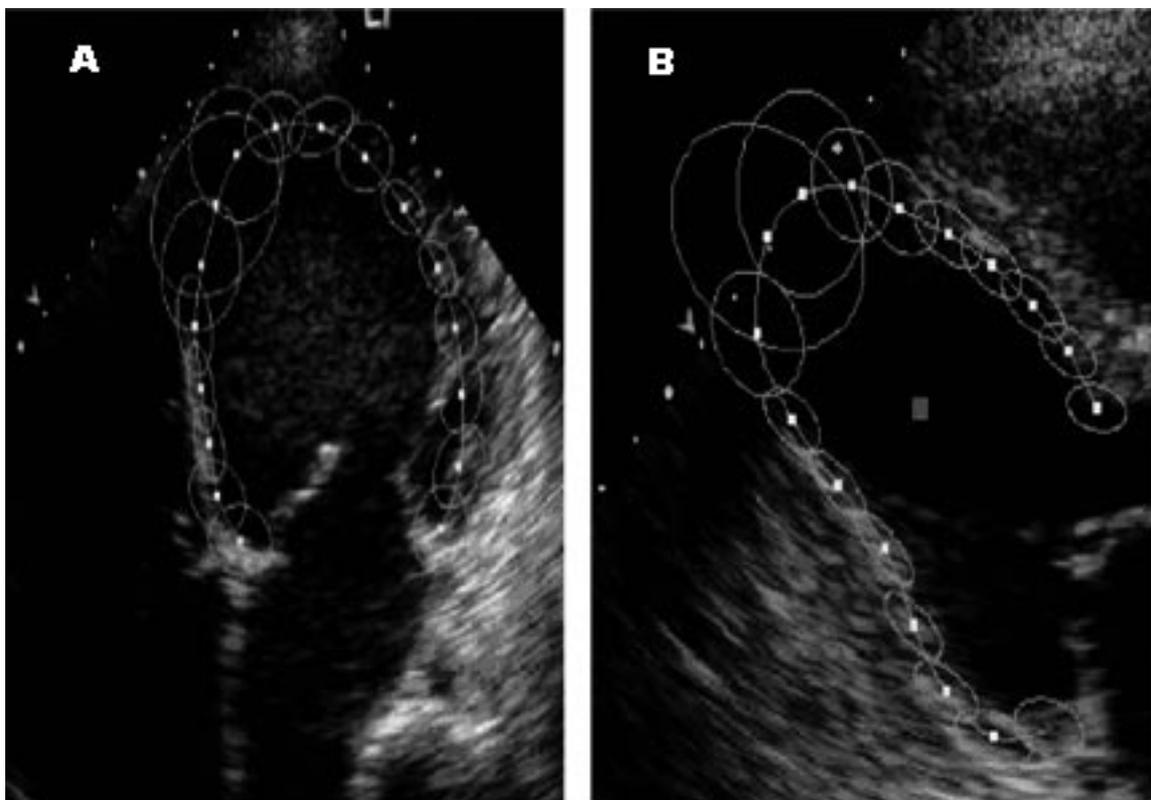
These apical four chamber views are obtained from two different patients undergoing a DSE study. The magnitude of the ellipses shows the uncertainties in motion estimation of the dots representing the endocardium in these examples. The larger the ellipse the bigger the uncertainty. In the panel A the uncertainties are largest in the distal/septal area while in panel B they are largest in the apex. This means that the system cannot accurately recognize the exact location of a certain landmark point in the next frame.
